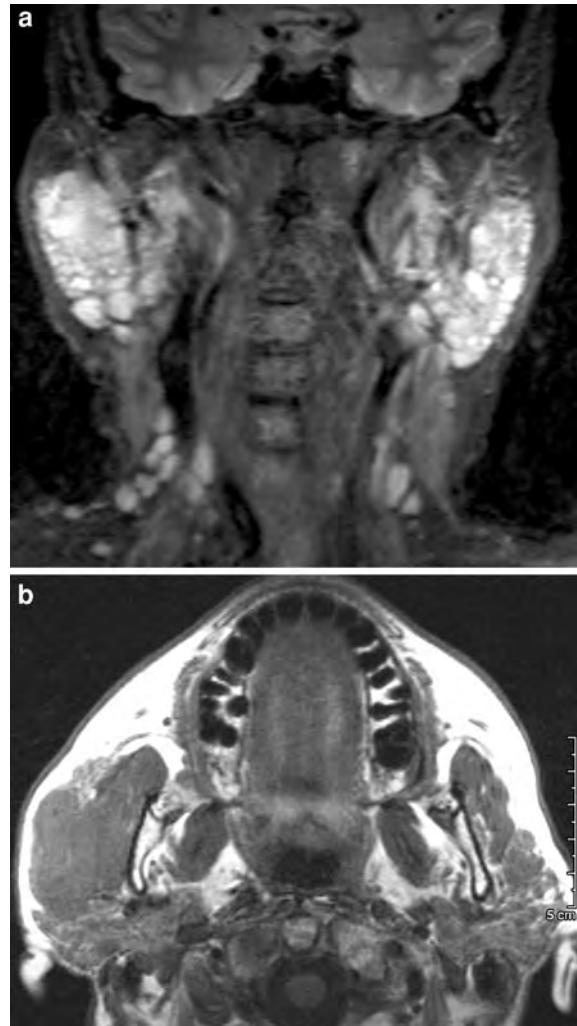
Primary MALT lymphoma of the parotid gland. A female patient with Sjögren's syndrome with progressive parotid enlargement. T2-weighted (TIRM) MR-images. a Coronal image confirms bilateral parotid swelling. This is caused by innumerable small cysts indicative of chronic sialadenitis with cystic enlargement of terminal salivary ducts. Note multiple non-enlarged level IV nodes bilaterally. b Axial image shows an additional infiltrative mass located in the superficial lobe of the right parotid gland invading the masseter muscle. Biopsy of this mass revealed MALT lymphoma
